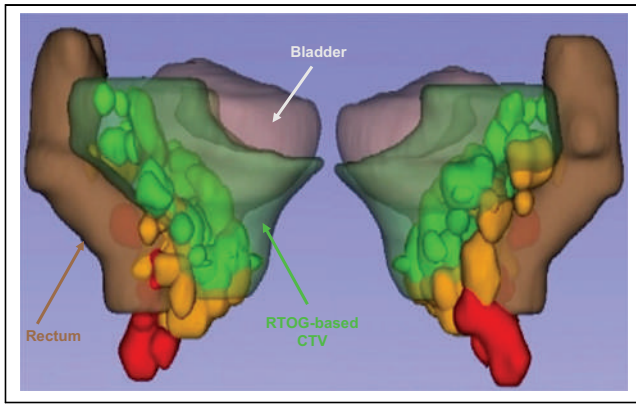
Three-dimensional rendering of all PB recurrences in relation to RTOG-based CTV (light green), rectum (brown), and urinary bladder (pink) of template patient. PSMA recurrences are in solid colors: green = completely covered, yellow = partially covered, and red = not covered.
